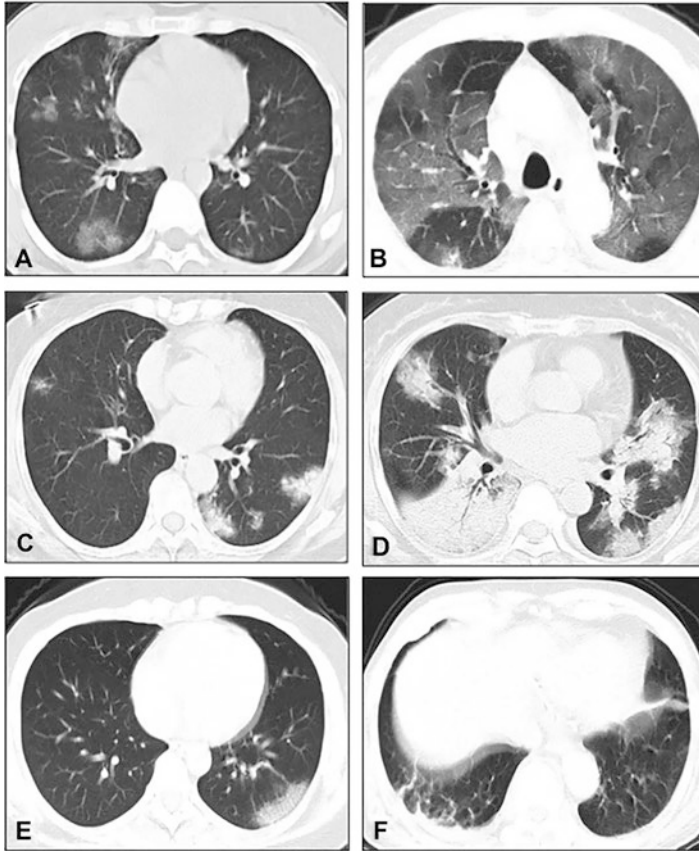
Computed tomography (CT) findings of confirmed coronavirus disease 19 (COVID-19) patients. *Note:* (a) Pneumonia ground-glass opacity (GGO); (b) GGO and air bronchogram in a patient with severe pneumonia; (c) consolidation in patients with pneumonia; (d) consolidation and air bronchogram in a patient with severe pneumonia; (e) nodular opacities in patient with pneumonia; (f) pleural effusion on right side in a patient with severe pneumonia. (Source: Liu et al. (2020b))
